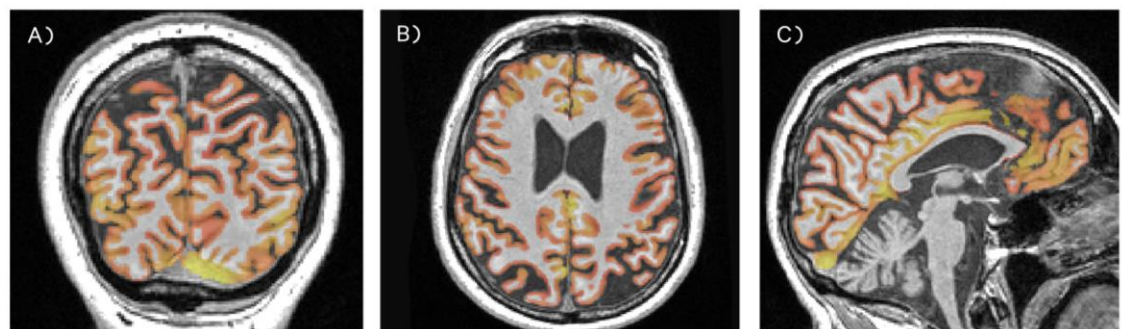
An example of a MALP-EM CT segmentation for a participant showing disease related atrophy shown in A) coronal, (B) axial and (C) sagittal views. Spillage of the CT segmentation into the occipital dura is particularly pronounced in the coronal and sagittal views.
